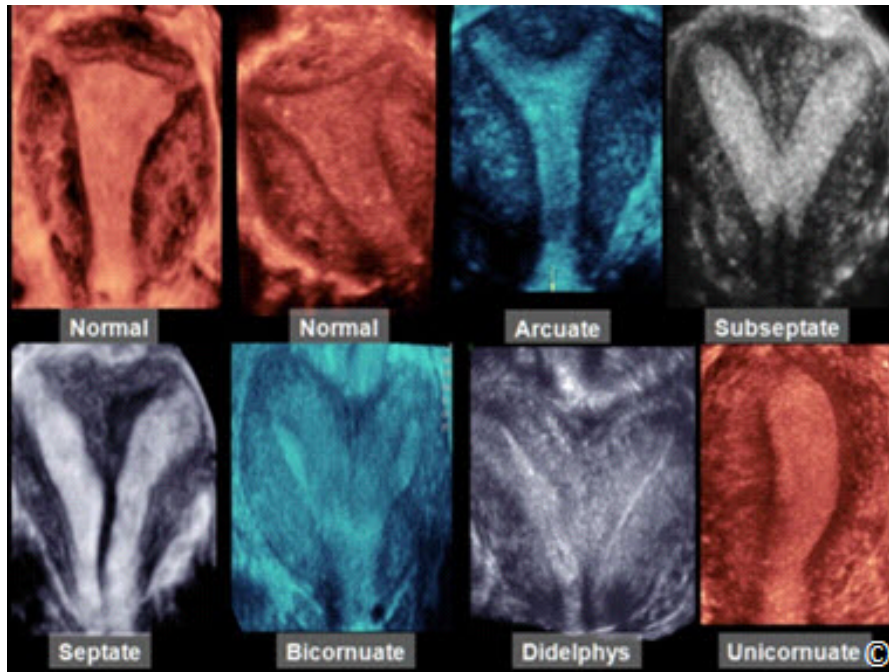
Midcoronal planes of uteri obtained from 3-D ultrasound volumes in normal and abnormal uterine abnormalities. Note the clear depiction of the serosal and endometrial fundi and lower-uterine segments, which allow for differentiation of various mullerian anomalies. See Table 11.3 for details. Modified with permission from the American Institute of Ultrasound in Medicine (18).
